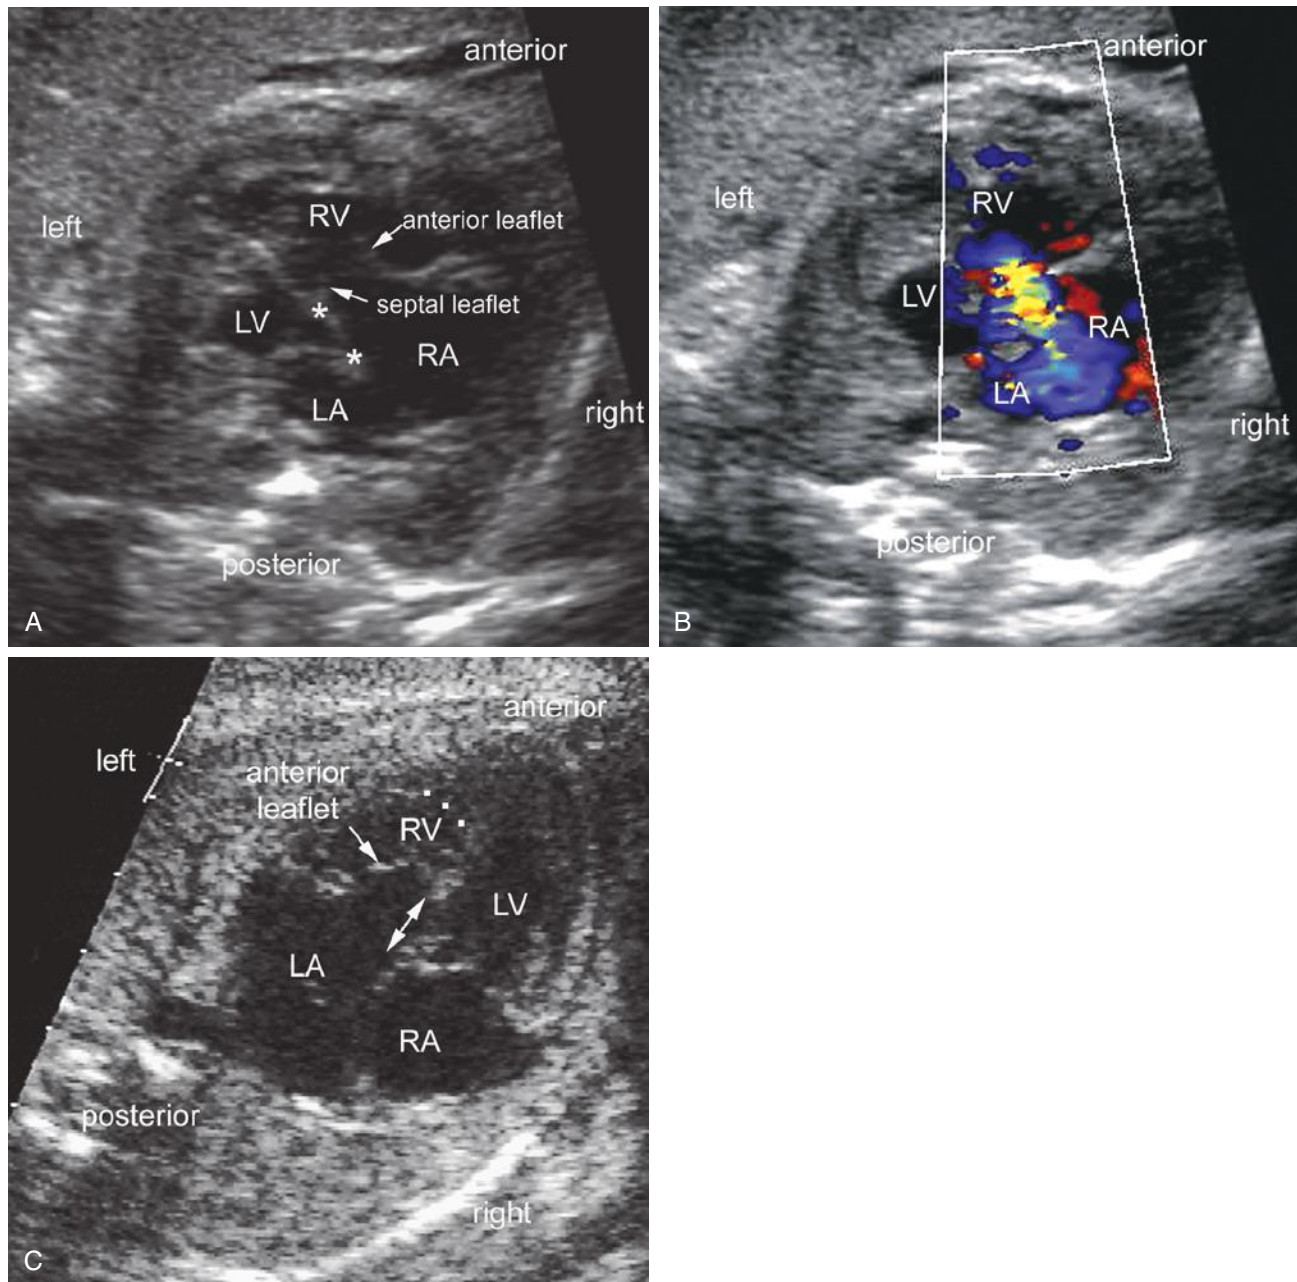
Ebstein malformation of the tricuspid valve. A, Four-chamber view shows a big heart with dilatation of the right atrium (RA) and right ventricle (RV). Note the displaced attachment of the septal leaflet of the tricuspid valve (*upper asterisk*). The anterior leaflet of the mitral valve has a normal insertion to the septum (*lower asterisk*). The anterior leaflet of the tricuspid valve is large, whereas the septal leaflet is small. B, Color Doppler image in the same view as A shows moderate tricuspid regurgitation. C, Ebstein malformation in a patient with congenitally corrected transposition of the great arteries (atrioventricular discordance with ventriculoarterial discordance). LA, left atrium; LV, left ventricle. (From Yoo SJ, Jaeggi ET: Ultrasound evaluation of the fetal heart. In Callen PW [ed]: *Ultrasonography in Obstetrics and Gynecology*. London, Elsevier Health Sciences, 2011, pp 511-586, used with permission.)
